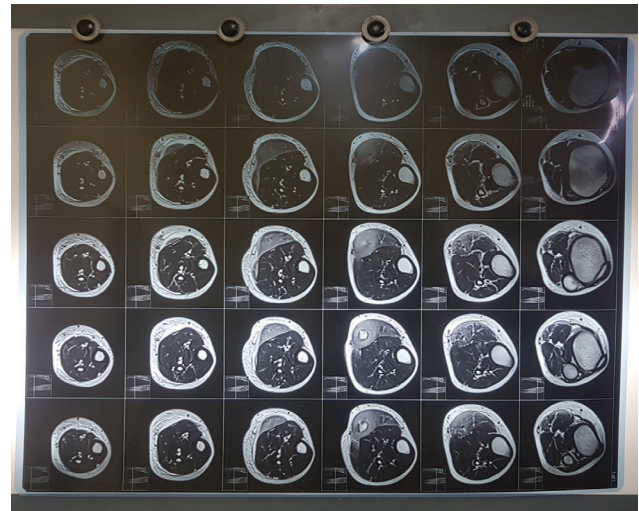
MRI of the lesion
